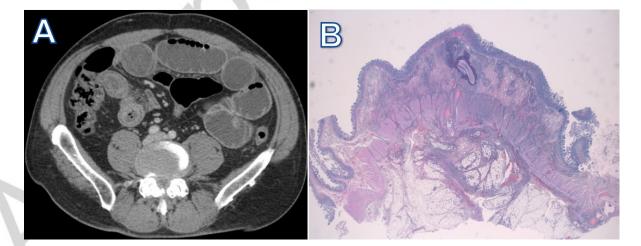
Computed tomography scan. Figure 1B: Pathology of resected small intestinal wall showing *Anisakis* larvae impacted in the submucosa and marked transmural inflammatory reaction.
